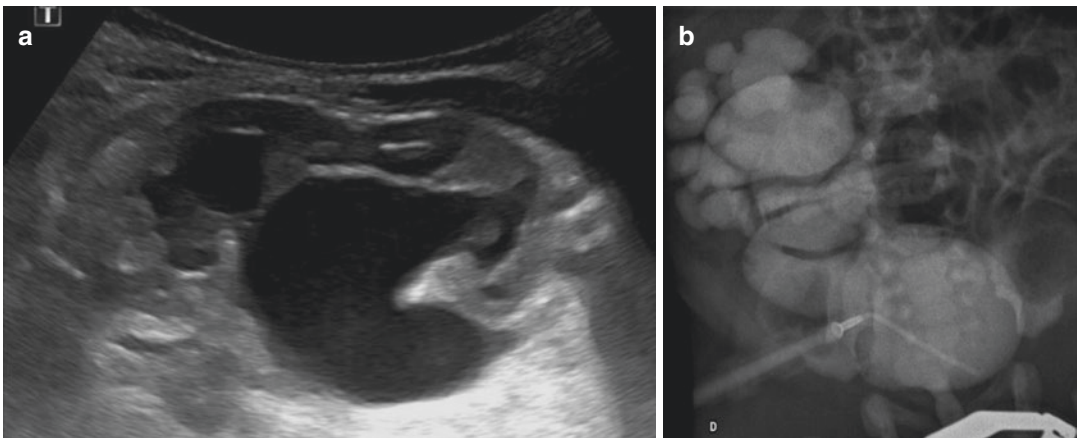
Hypodysplasia and vesico-ureteric reflux. (a) Ultrasound sagittal scan of the right kidney showing marked dilatation, loss of CMD in a small kidney (3 cm). (b) VCUG: massive grade V r right reflux into the right kidney
